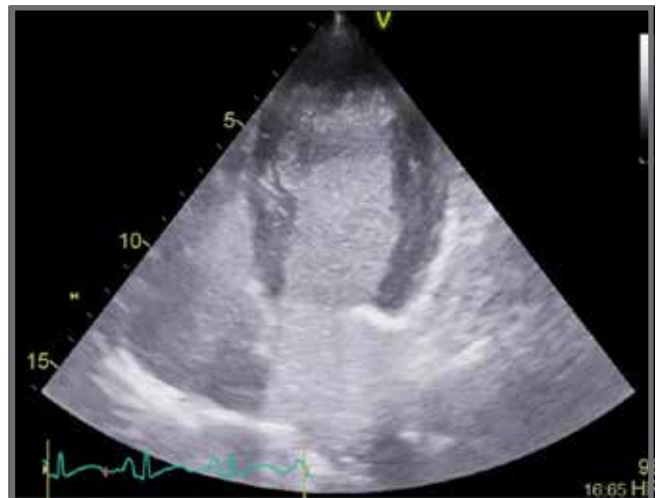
4CH transthoracic transpulmonary contrast echocardiography
